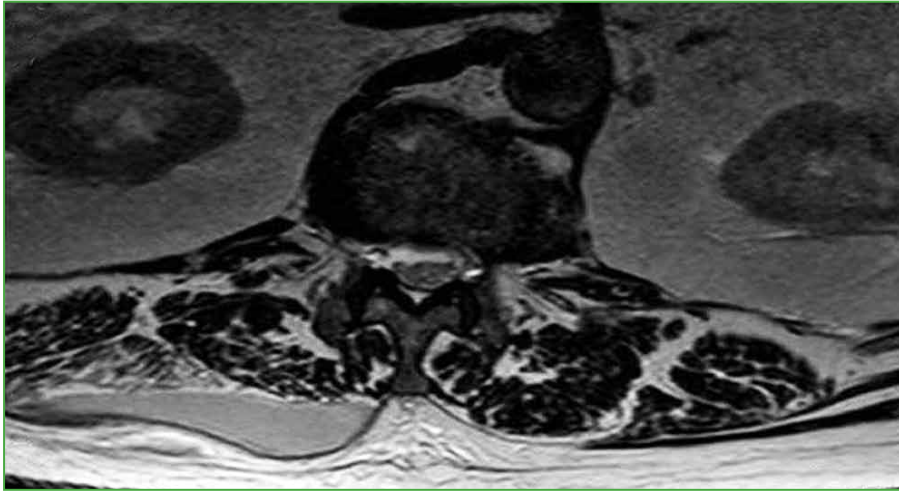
Axial view of an MRI of L1 showing a subaponeurotic fluid collection at the level of the right paraspinal muscles.
